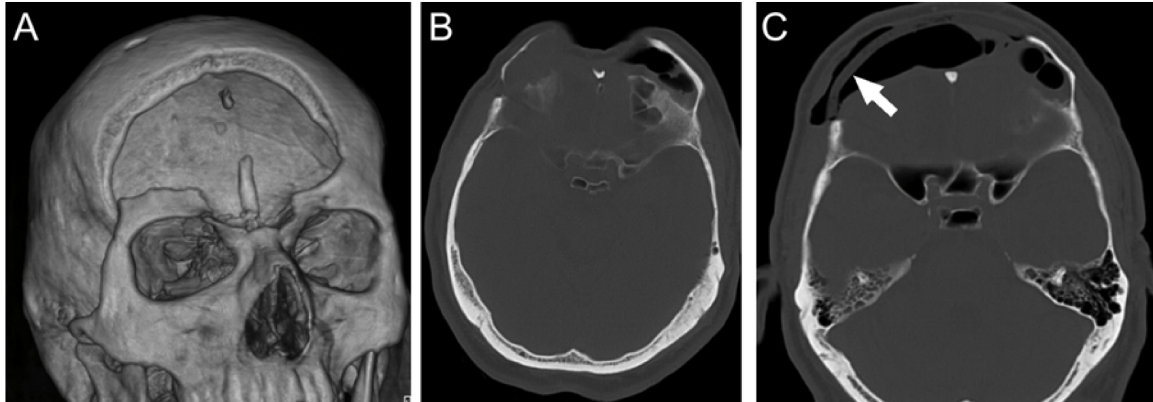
A. Stereotactic three-dimensional reconstruction of the cranial defect after the initial surgery demonstrating the large defect involving the frontal ethmoid and orbital bones. B. Axial CT image of bone windows demonstrating the cranial defect. C. Postoperative axial CT image of bone windows demonstrating the Medpor implant with smooth margins (arrow).
